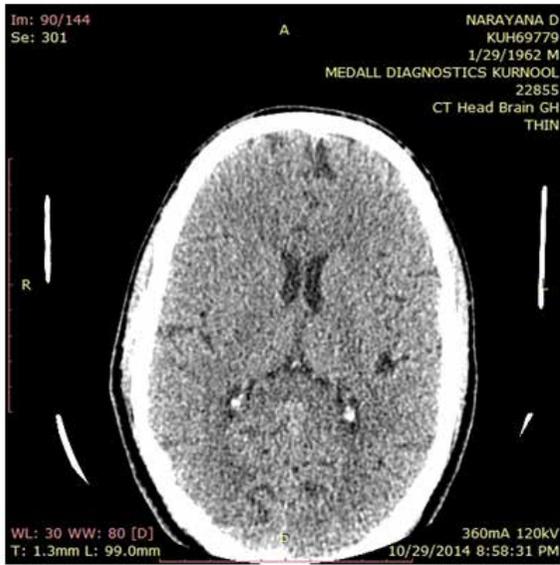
CT brain showing right frontal hypodensities – suggestive of acute infarct.
